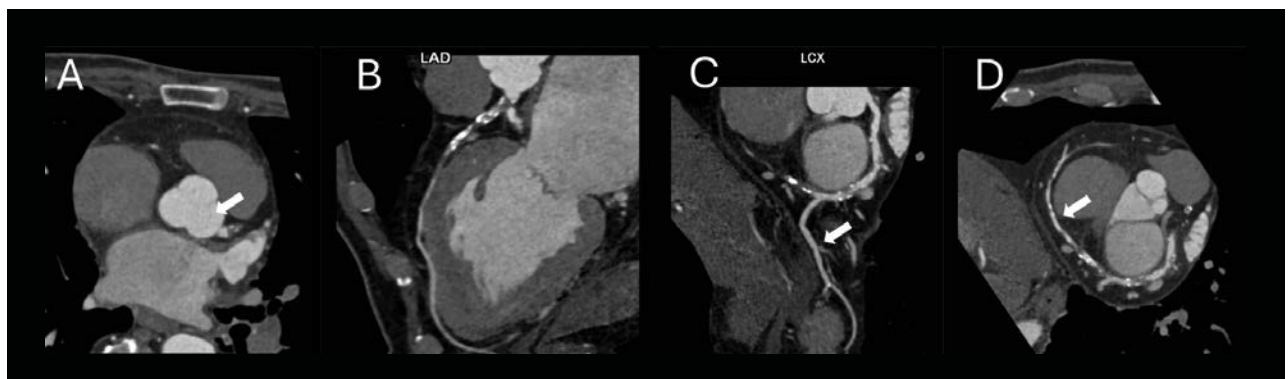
Coronary CT angiogram images obtained through curved range radial multiplanar reformation (MPR) demonstrate an isolated LMCA originating from the left coronary cusp (arrow in Fig 2A). The LMCA gives rise to LAD (Fig 2B) and LCx artery (Fig 2C). The LCx (arrow in Fig 2C) is a long, dominant vessel that traverses the left atrioventricular groove, courses through the crux of the heart, and continues into the right atrioventricular groove, ultimately forming the right coronary artery (arrow in Fig 2D). Significant calcified and non-calcified plaque burden is observed in all three coronary arteries, resulting in varying degrees of stenosis.
